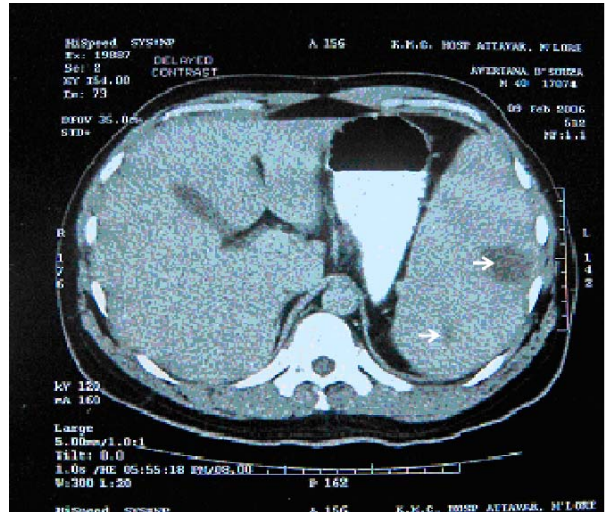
CT scan abdomen showing two ill defined peripheral wedge shaped hypodense parenchymal lesions in the spleen suggestive of infarcts.
